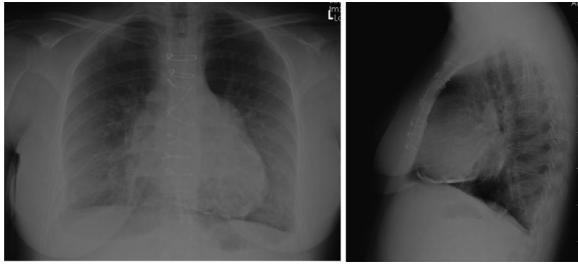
Linear hyperdensity surrounding the heart suggesting calcification on the posteroanterior and lateral view (Chest X-ray).
